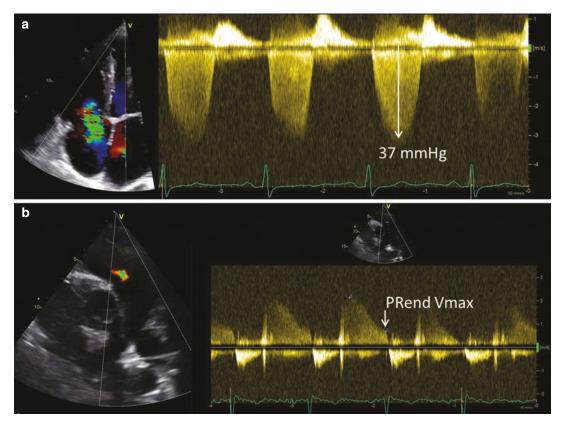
Estimation of right ventricular systolic pressures and diastolic pulmonary arterial pressure. From the spectral signal on continuous wave Doppler of the tricuspid regurgitant jet, the peak velocity can be measured and, with the modified Bernoulli equation, the pressure gradient can be calculated (panel a). By adding the right atrial pressure, the right ventricular systolic pressures can be
